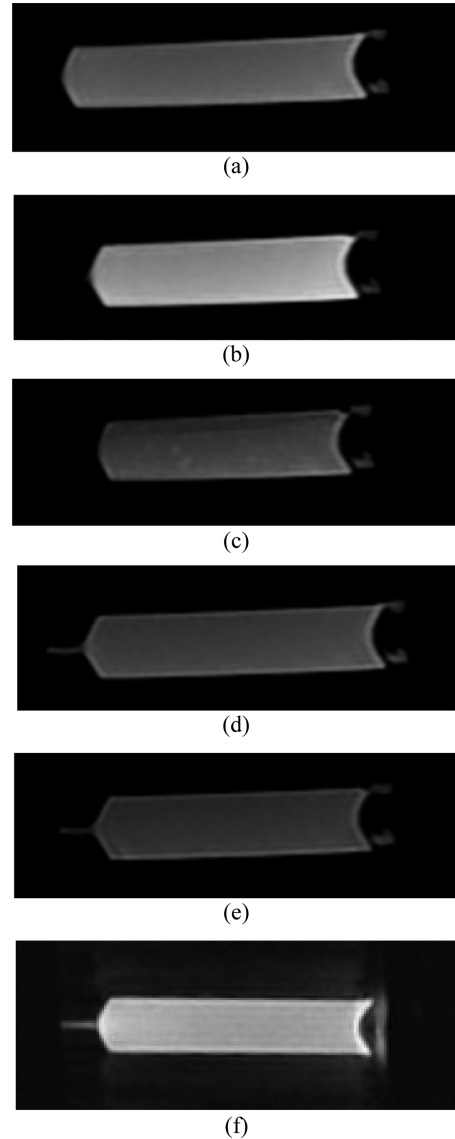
Each contrast media was examined using a T1-weighted sequence. The contrast media used were Solotop[®] (a), Gastrografin[®] (b), 50 % blueberry juice (c), 100 % orange juice (d), 3.5 % blueberry juice (e), and water (f).
